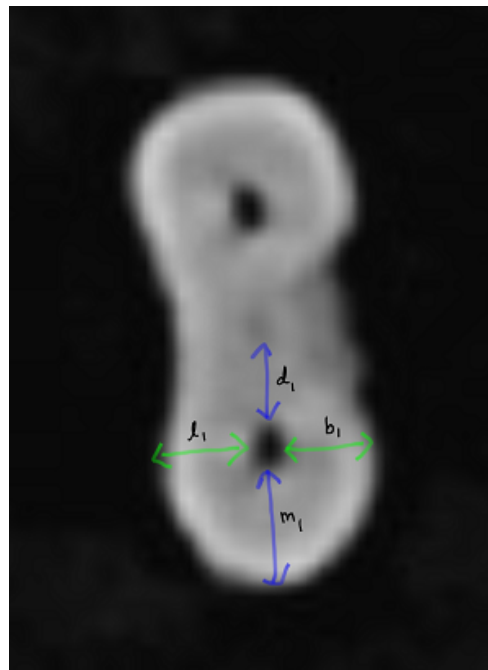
The transportation in the mesiodistal and buccolingual direction was estimated by superimposing pre- and postoperative CBCT images using Image J software at 3mm, 6mm and 9mm from the apex
